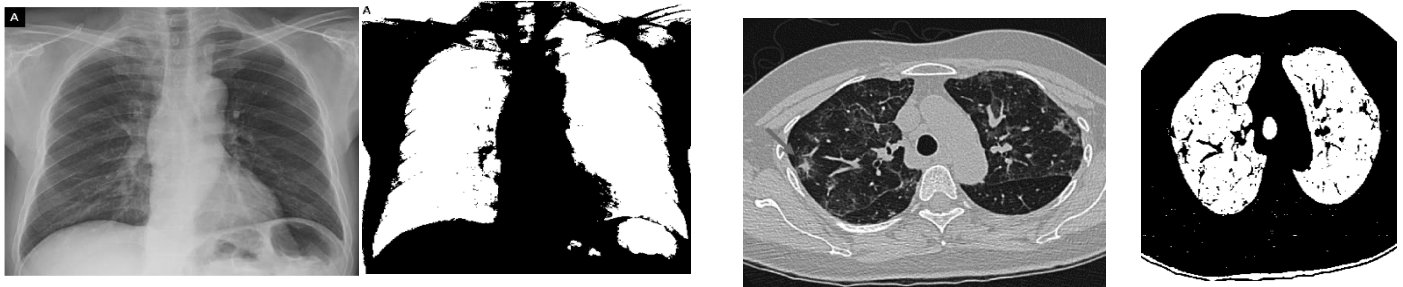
Thresholding segmentation for corona lung of x-ray image
